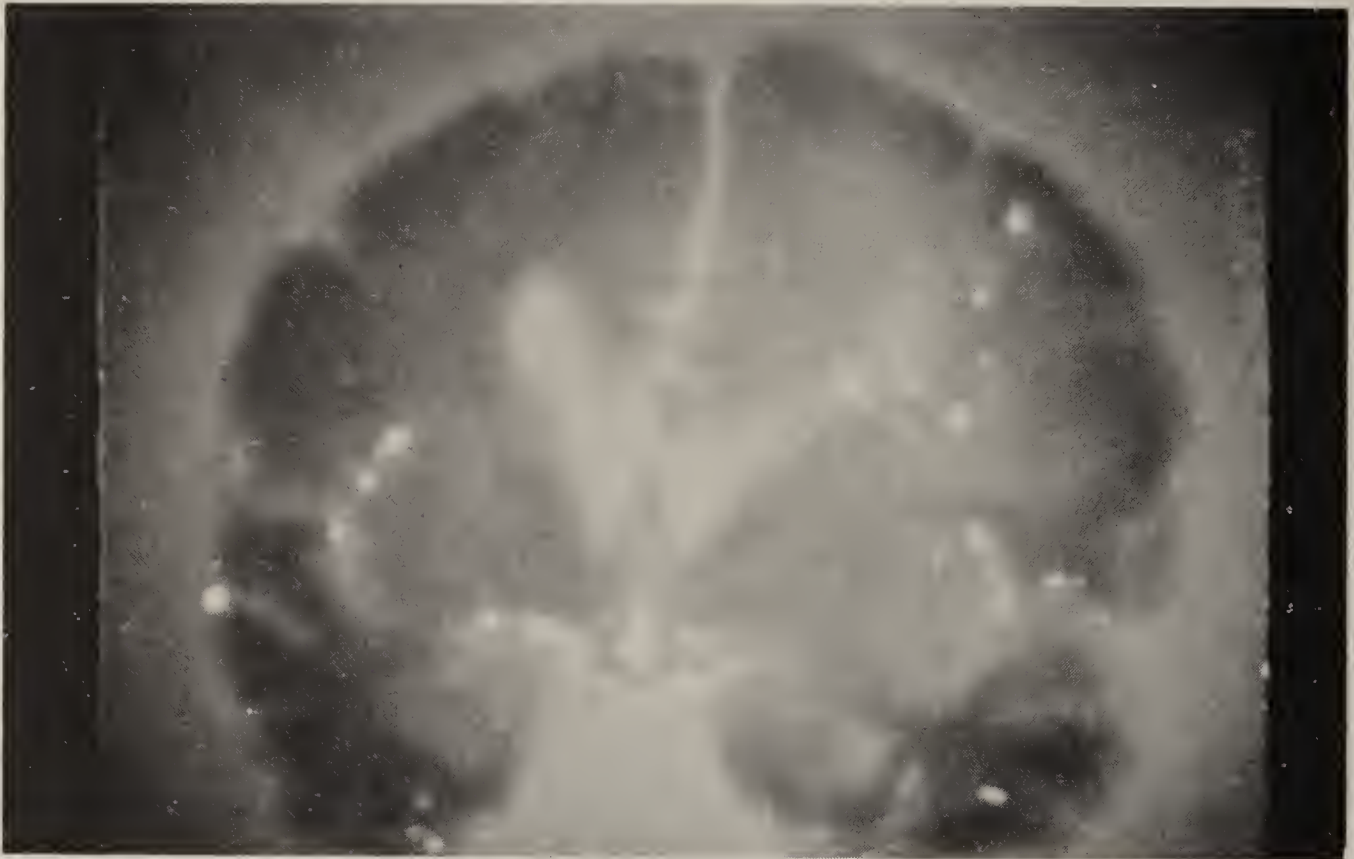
Proton radiograph (positive). Note decreased density in the tumor area and visualization of the basal ganglia. White spots are air bubbles. The conditions were 115 cm focus to film, no screen, Polaroid TLX film, and a dose to the first surface of approximately 290 rad in 0.8 minute.
